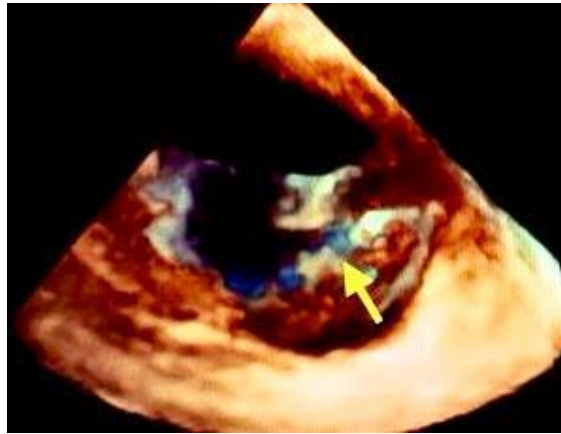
3-Dimensional echocardiography. Three-dimensioned echocardiogram showing cleft mitral valve.
